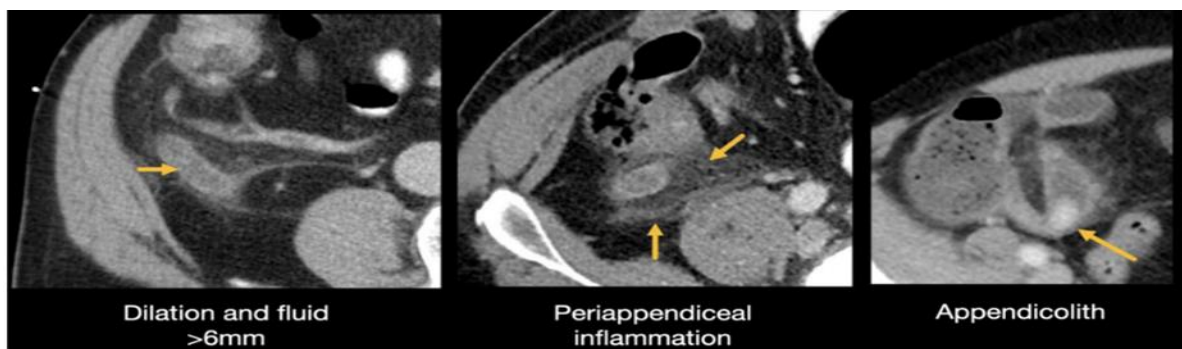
CT images of acute appendicitis (transversal sections)
